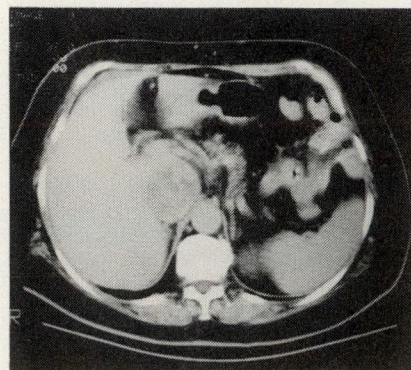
Case 2. Preoperative abdominal computed tomogram showing tumour thrombus within enlarged inferior vena cava.
